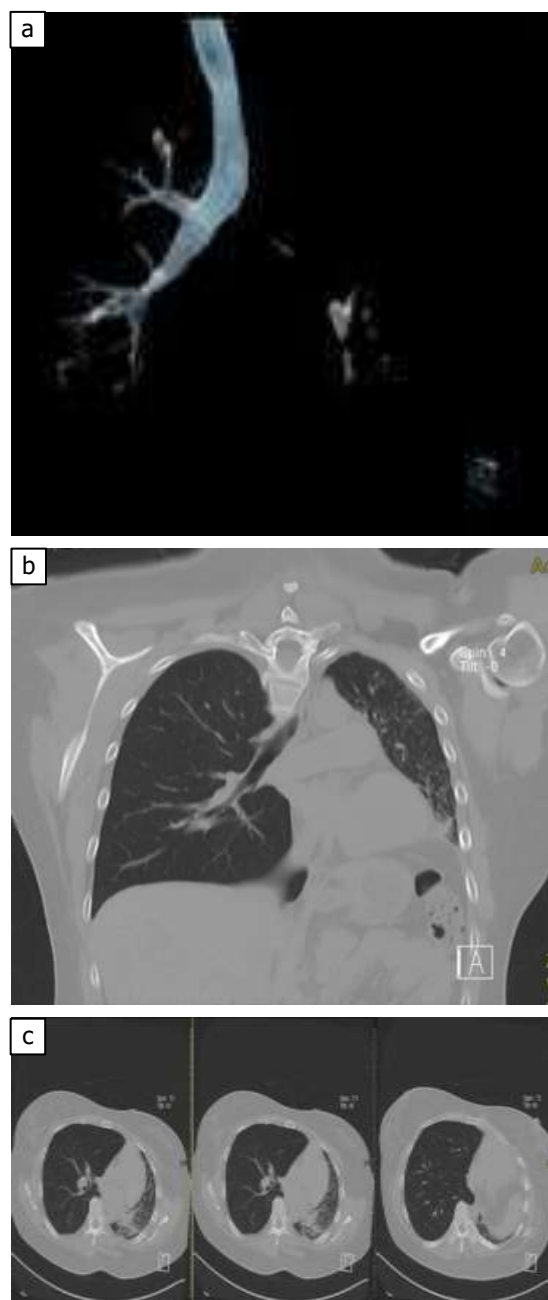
(a) A 3D-CT scan of the lung demonstrates stenosis of the left main bronchus; (b) Axial chest CT scan; (c) Coronal view
